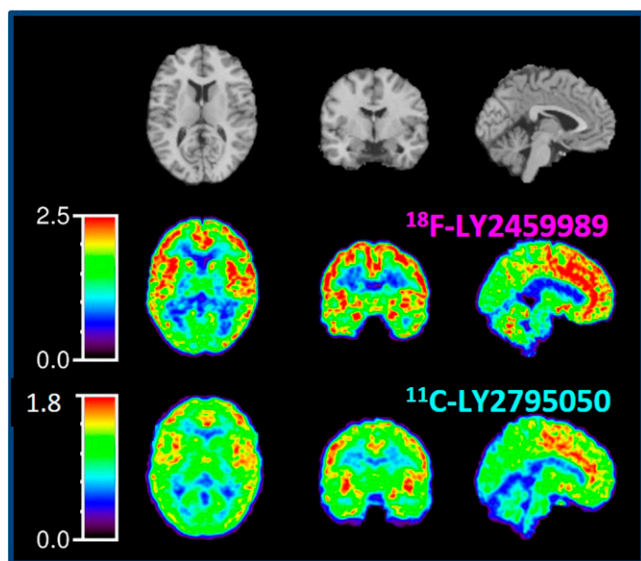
^{18}F -LY2459989 imaging of the kappa opioid receptor in humans (middle row) compared with ^{11}C -LY2459989 PET imaging (bottom row). Comparison MR images in the same healthy subject are shown in the top row. The ^{18}F -labeled tracer showed favorable kinetic and binding characteristics, making it suitable for PET imaging and quantification of kappa opioid receptors in the human brain.
